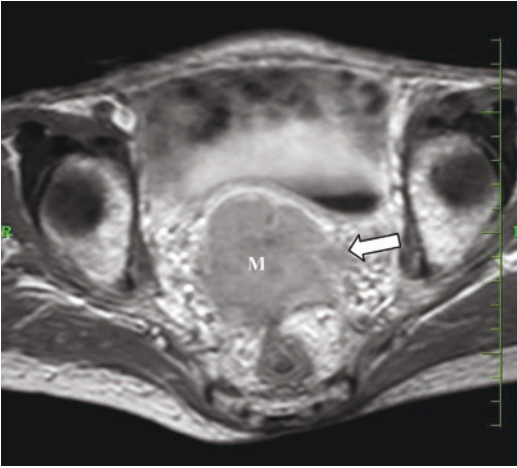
Cervical cancer with parametrial invasion. Axial T1 contrast MRI showing an enhancing cervical mass (M) with bilateral parametrial infiltration (more on left) (arrow)
